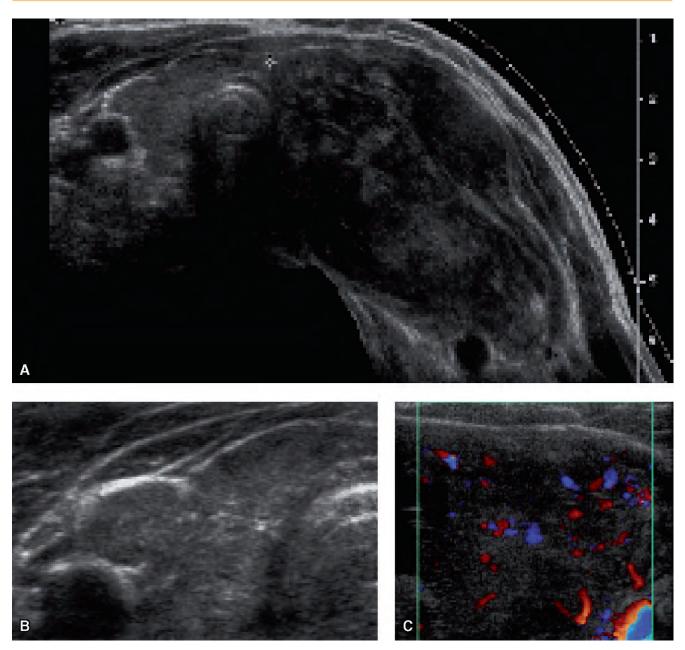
A and C, Ultrasound of lymphoma in the left lobe. B, Thyroiditis in the right lobe.
